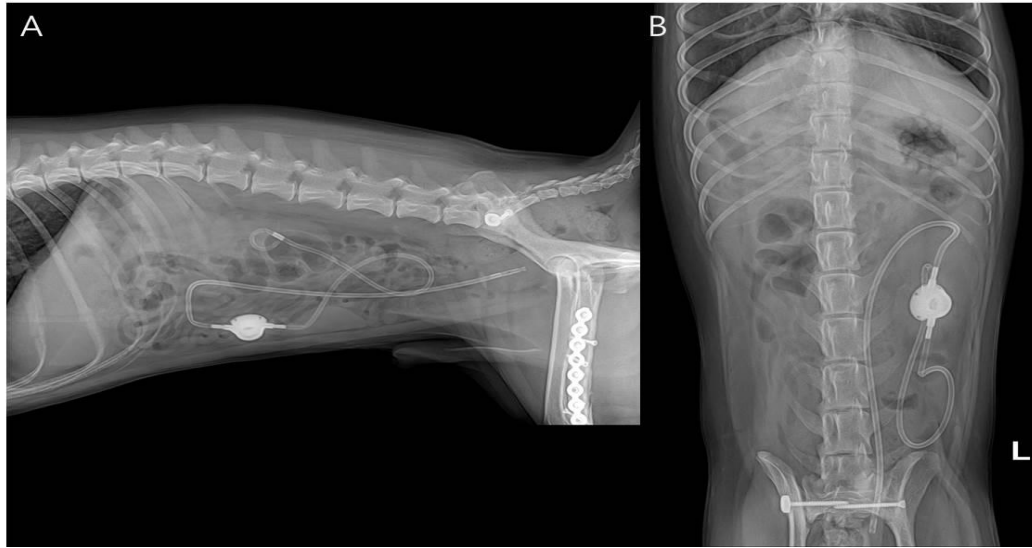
Radiographic images of postoperative (after one month) follow up of nephrovesical subcutaneous ureteric bypass placement. (A) Lateral view and (B) Vento-dorsal view. The images showing that proper settings of locking loop nephrostomy catheter and the cystostomy catheter with the subcutaneous port.
